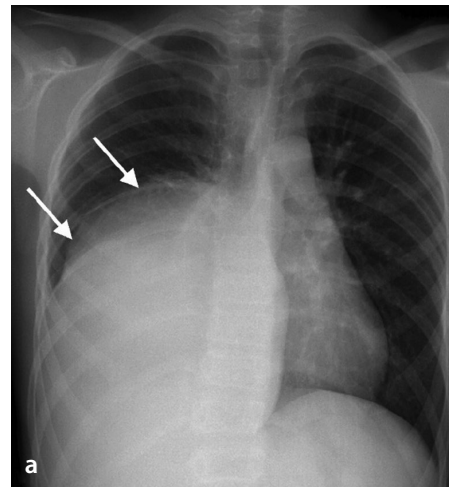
(a, b) An 11-month-old boy with mature cystic teratoma. (a) The chest X-ray shows large opacity in the lower zone of the right lung. (b) The axial chest computed tomography image demonstrates a large cystic mass with calcification (black arrow) and a nodular solid component (not shown).
